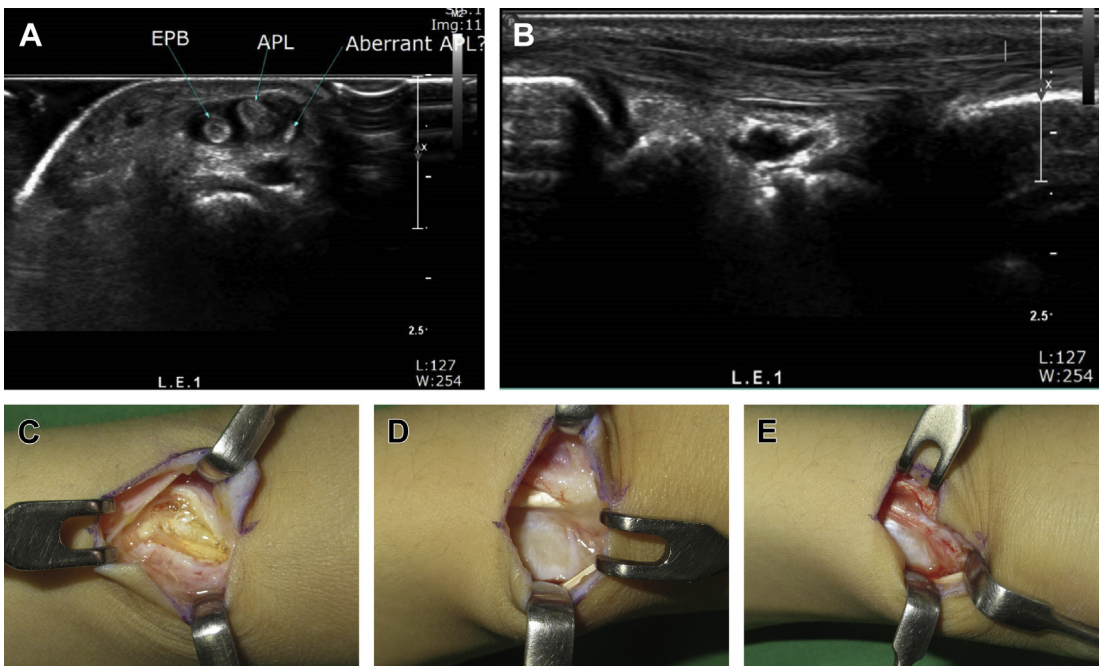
A 28-year-old female golfer developed serious pain on the first extensor compartment. (A, B) On the axial and longitudinal ultrasonography views, aberrant APL tendon with fluid collection was found within the first extensor compartment. (C) Through the zigzag skin incision, the most dorsal part of the first extensor compartment opened revealing fluid collection and longitudinal rupture of the tendons. (D) Inside the first compartment, there was a septum with an aberrant tendon. (E) Intracompartmental septum was completely released.
